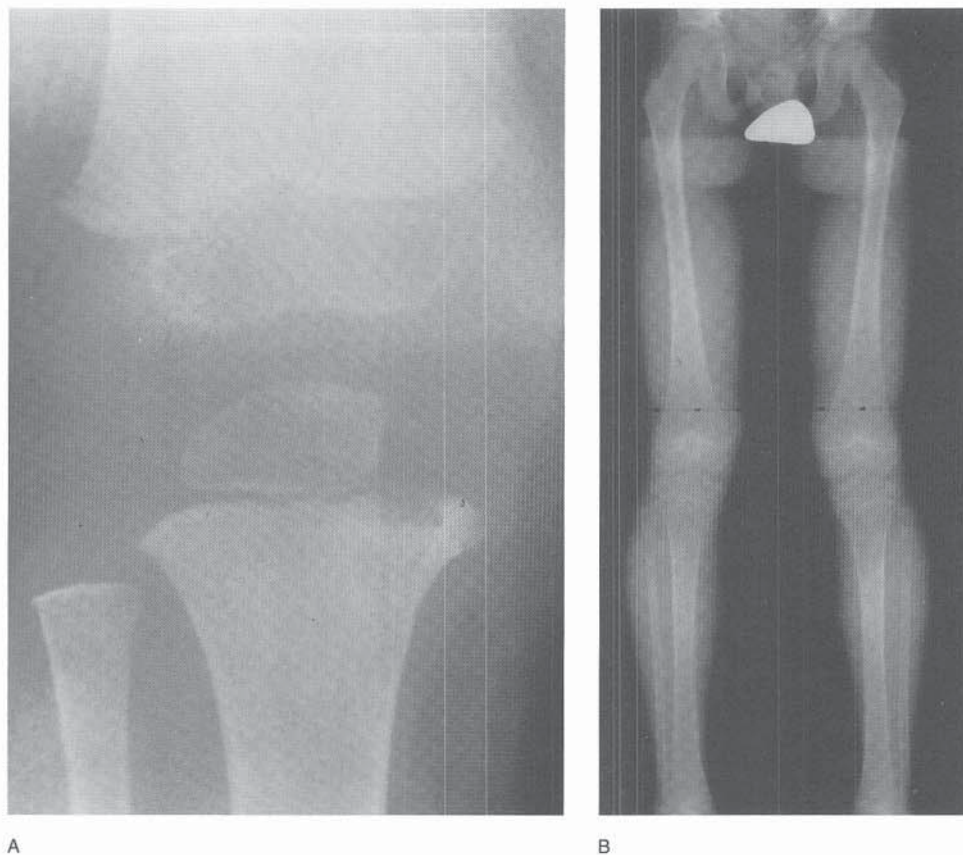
Epiphyseal subacute osteomyelitis. A, AP radiograph of the knee shows lytic lesion involving the proximal tibial metaphysis and epiphysis. B, Standing AP radiograph of the lower extremities obtained 5 years after treatment shows normal growth of the proximal right tibial physis.
